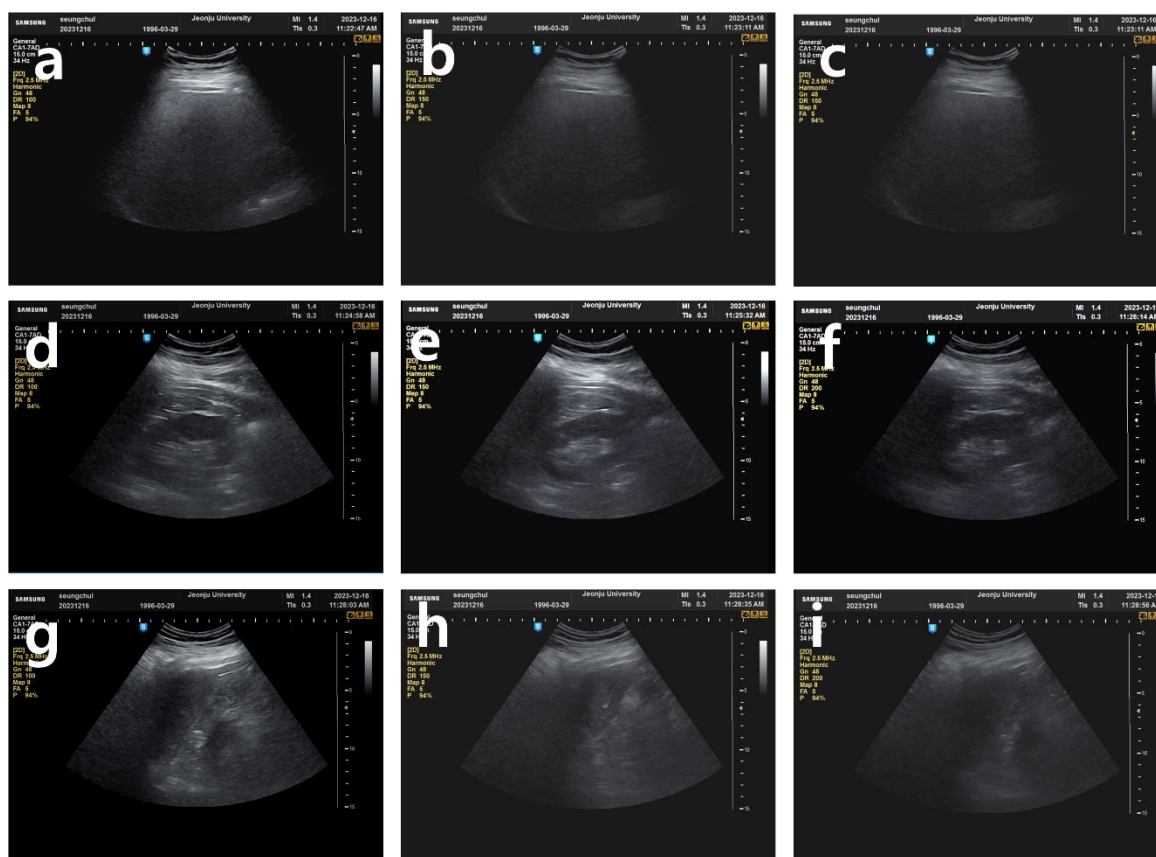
Ultrasound images of the liver, spleen, and kidney were obtained at regions with minimal intraparenchymal vascular structures using an abdominal imaging protocol. Each organ was scanned under identical conditions without TGC adjustment, with dynamic ranges (DR) set to 100, 150, and 200. Quantitative image analysis was performed using ImageJ software (National Institutes of Health, USA). For reference, the datasets were labeled as follows: a = DR 100 Liver, b = DR 150 Liver, c = DR 200 Liver; d = DR 100 Kidney, e = DR 150 Kidney, f = DR 200 Kidney; g = DR 100 Spleen, h = DR 150 Spleen, i = DR 200 Spleen.
